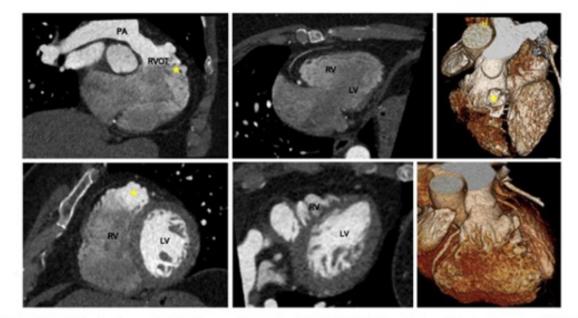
Cardiac CT study showing morphological changes of the right ventricle (RV) with right ventricular outflow tract aneurysms (RVOT) (*). PA– Pulmonary artery, LV – Left ventricle.
